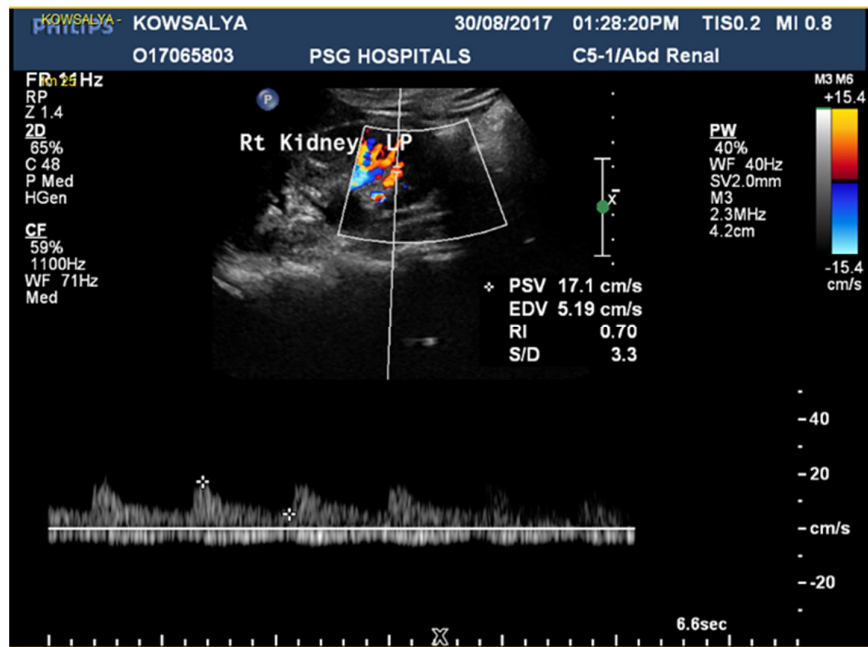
(D) Doppler US demonstrating an RI value of 0.70 in the lower pole of right kidney (obstructed).
